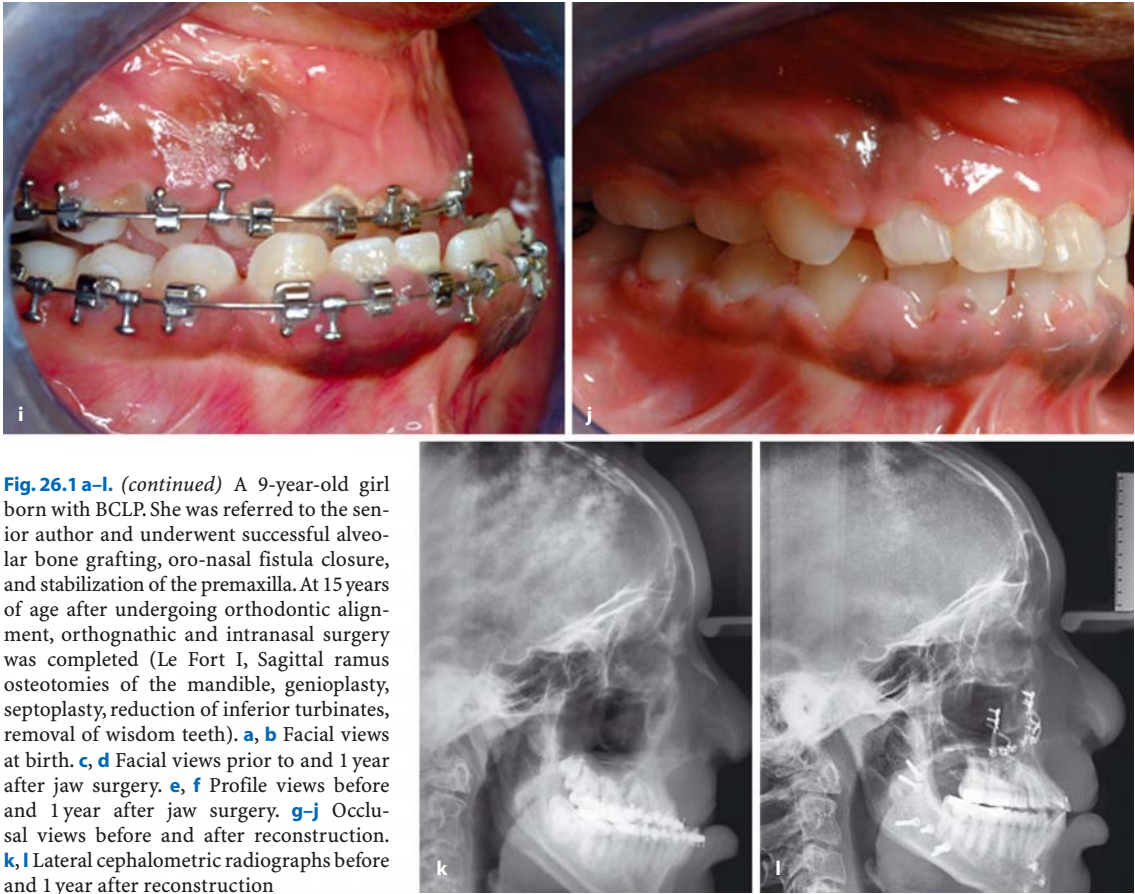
a–l. (continued) A 9-year-old girl born with BCLP. She was referred to the senior author and underwent successful alveolar bone grafting, oro-nasal fistula closure, and stabilization of the premaxilla. At 15 years of age after undergoing orthodontic alignment, orthognathic and intranasal surgery was completed (Le Fort I, Sagittal ramus osteotomies of the mandible, genioplasty, septoplasty, reduction of inferior turbinates, removal of wisdom teeth). a, b Facial views at birth. c, d Facial views prior to and 1 year after jaw surgery. e, f Profile views before and 1 year after jaw surgery. g–j Occlusal views before and after reconstruction. k, l Lateral cephalometric radiographs before and 1 year after reconstruction
